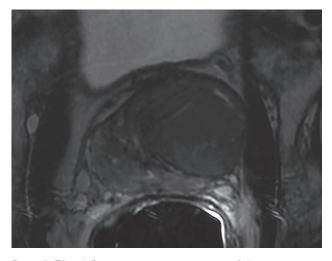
T2-w 1.5 magnetic resonance imaging of the prostate apex showed the presence of a capsule (low signal intensity complete line).
